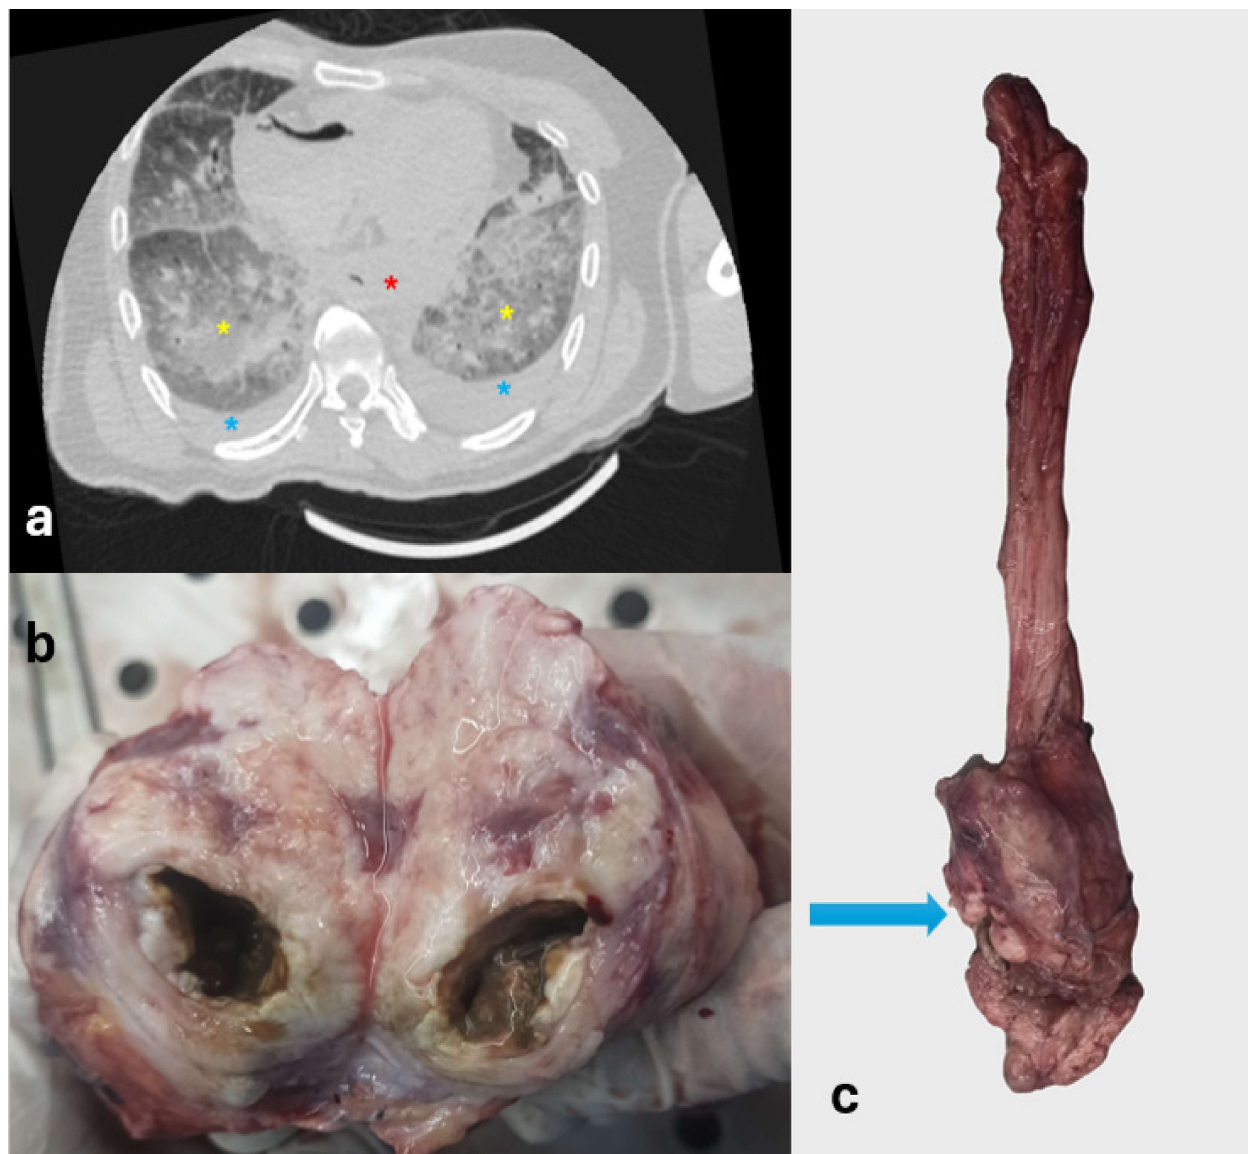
A: Postmortem CT axial section in lung window showing a hyperdense mass at the lower end of the esophagus (Red Asterix), bilateral pleural effusion (Blue Asterix) and bilateral ground-glass opacities along with interlobular septal thickening (Yellow Asterix); B: The cut section of esophageal mass showing irregular and uneven margins, and areas of necrosis; C: showing a mass located at the lower end of the esophagus (Blue arrow).
